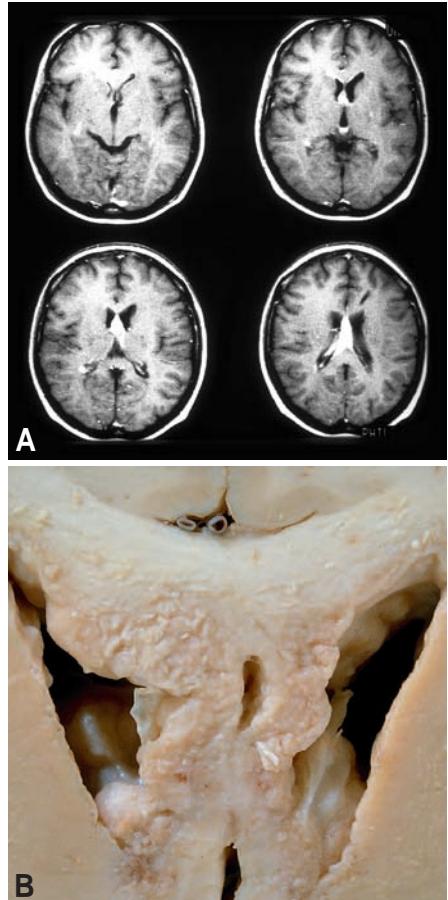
A Malignant lymphoma. T1-weighted MRI and (B) macroscopic appearance of malignant lymphoma with diffuse infiltration of the ventricular walls.
